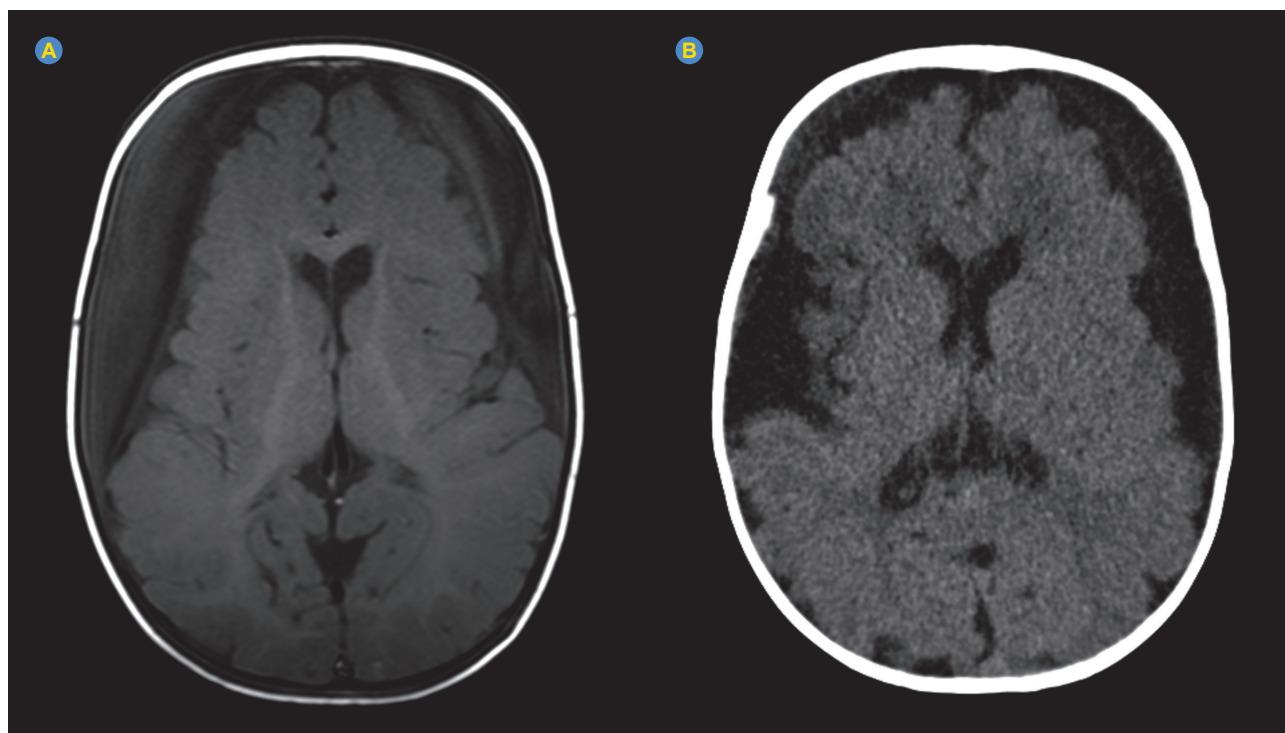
T1-weighted sequence from the MRI examination performed at 8 months of age (A) side-by-side with a cranial CT-scan at 9 months of age (B), reformatted to be in the same plane. Image (B) shows a marked reduction in size of the bilateral subdural hematomas and of their mass effect compared to image (A), now measuring 10 mm on the right convexity and 20 mm on the left.
